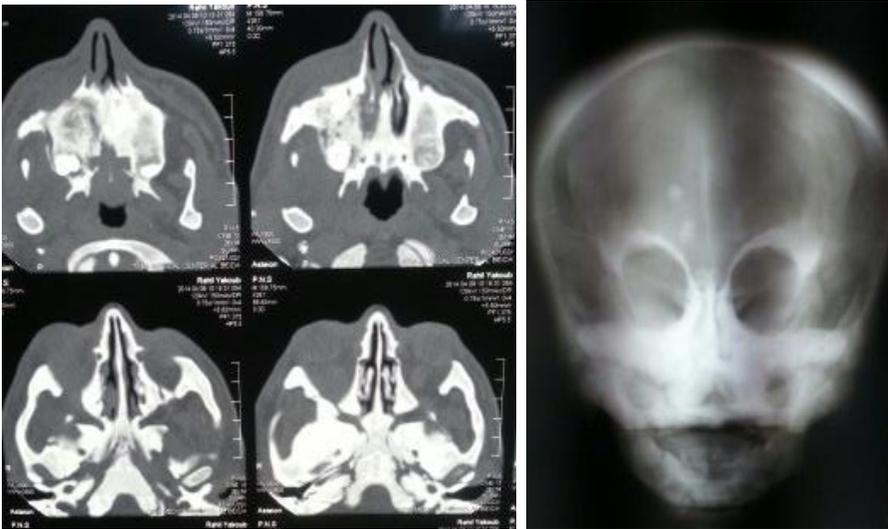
Coronal CT scan and PA skull views showed increased bone density especially at the skull base, zygoma, and maxilla with obliteration of paranasal sinues. On the right side of the maxillary bone, CT scan revealed bone irregularities that may indicate the bone sequestra.
